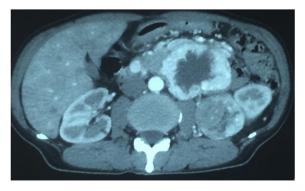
Abdominal CT scan showing a left renal lesion of 11 cm, isodense with heterogeneous enhancing associated to a pancreatic tissular lesion with a cystic central component.
